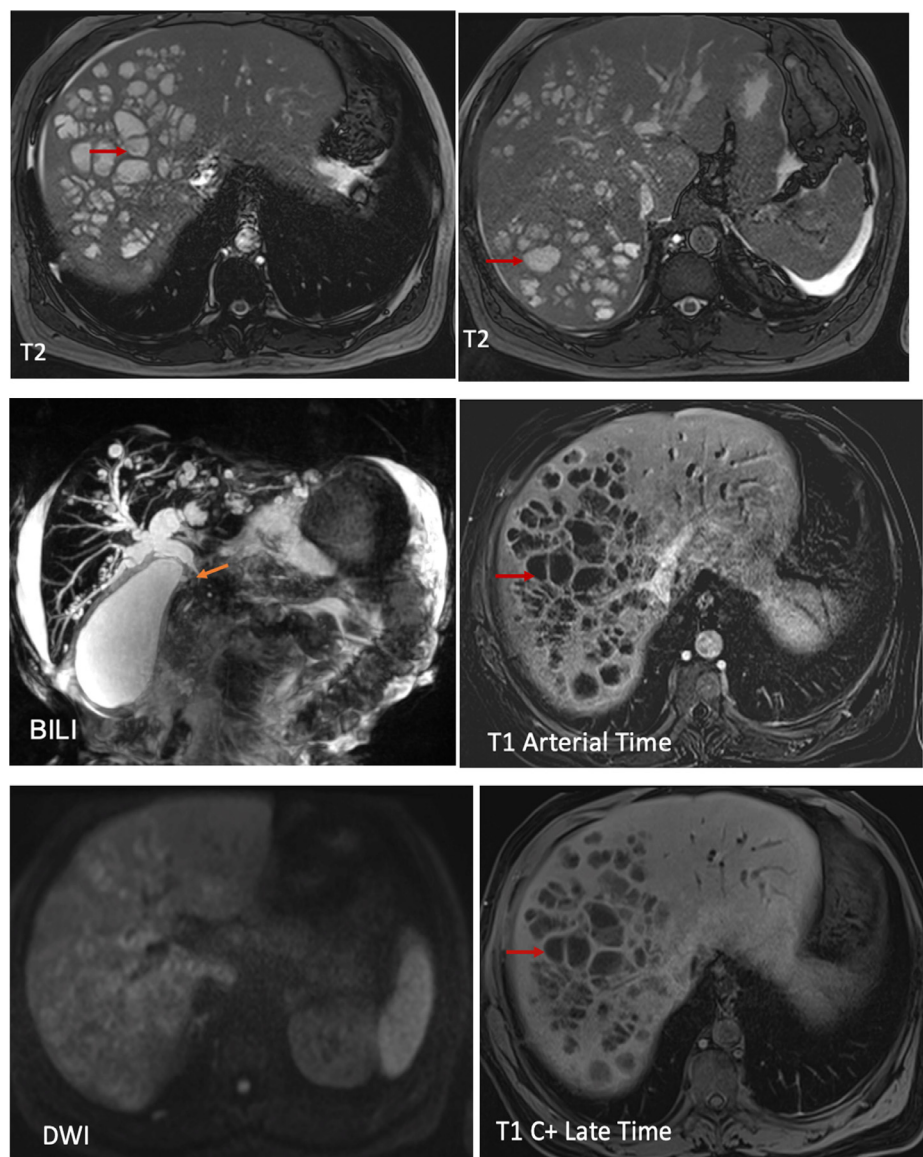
MRI in axial and coronal sections, showing multiple cystic lesions on either side of the portal branches (red arrow), described in T2 fluid hypersignal, nonrestrictive in diffusion, and not enhanced after arterial and late contrast. On the BILI sequence: dilatation of the intrahepatic bile ducts and the main bile duct upstream of a tumor-like stenosis of the middle part of the main bile duct (orange arrow).
